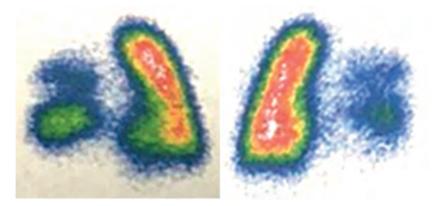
Child U.M., Preoperative perfusion lung scintigraphy (explanations in the text)
